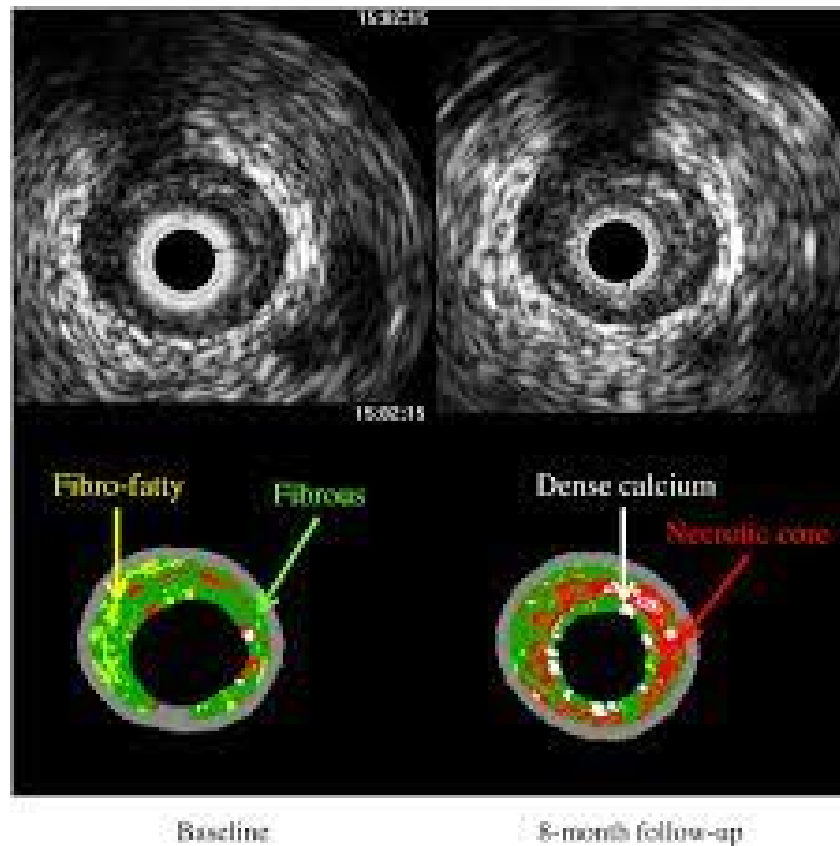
Intravascular Ultrasound
